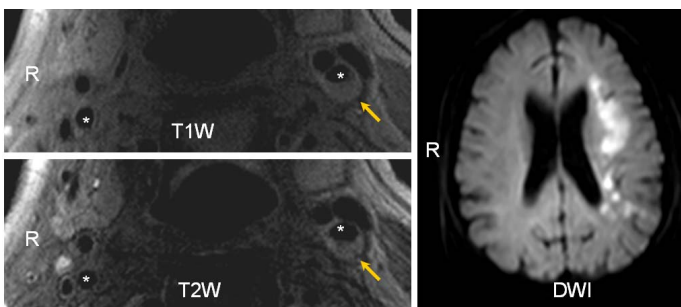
Eccentric atherosclerotic plaque (arrow) at left carotid artery (star) and a large territorial hyperintense area in left cerebral hemisphere were found on DWI in a 67 year old male patient.
